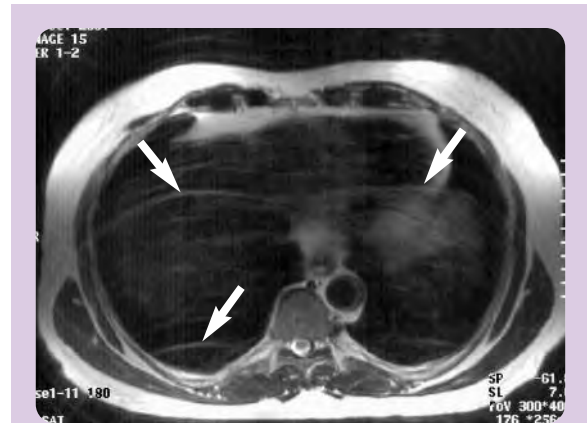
Respiratory artifact shown on an axial T2-weighted imaged.
